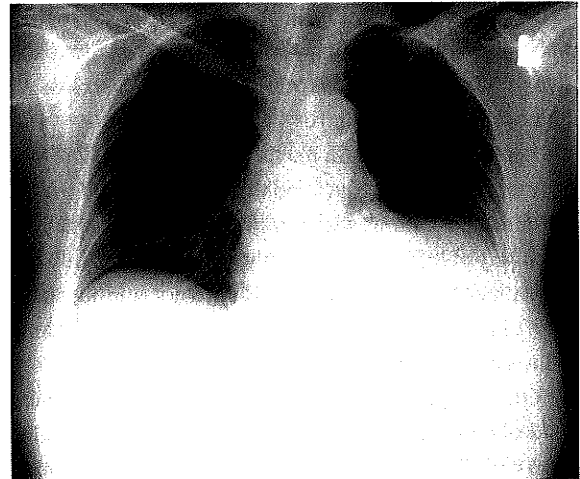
Frontal chest radiograph.
